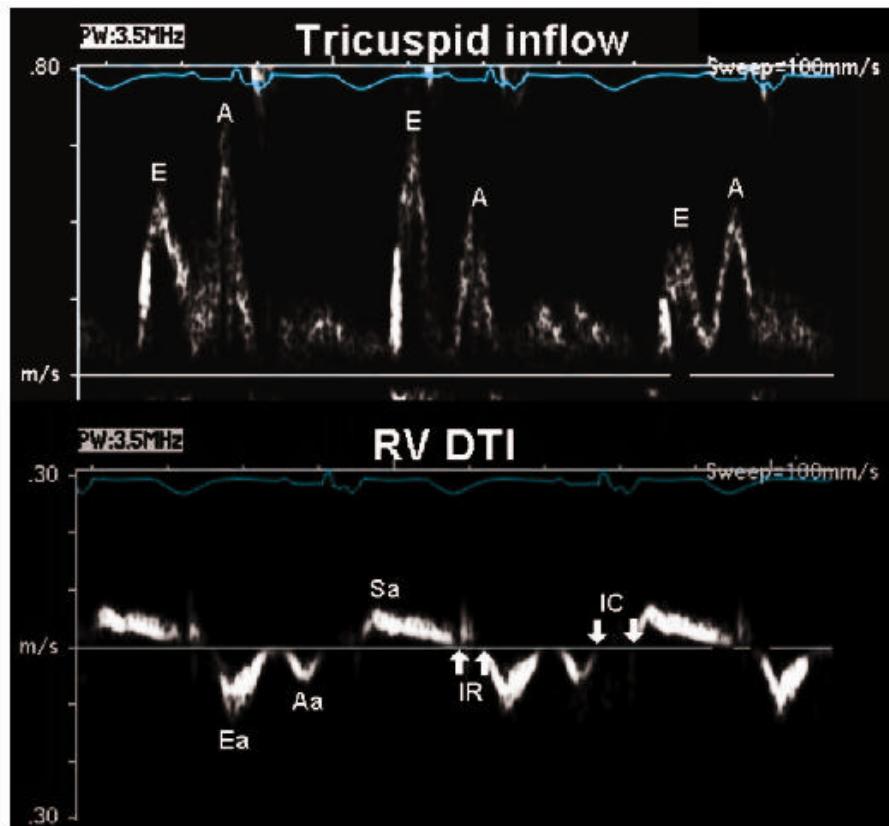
Tricuspid inflow Doppler (top panel) and tricuspid annular pulsed DTI (bottom panel) recordings from a child with tetralogy of Fallot after repair with severe pulmonary insufficiency. The tricuspid inflow Doppler pattern is difficult to interpret because of marked variations in velocities with changes in respiration. In contrast, the DTI tracing is stable throughout the respiratory cycle, reflecting the preload independence of annular motion. In addition, both systolic indexes of annular motion, such as peak systolic velocity (*Sa*) and isovolumic contraction (*IC*), and diastolic indexes of annular motion, such as early diastolic velocity (*Ea*), diastolic velocity with atrial contraction (*Aa*), and isovolumic relaxation (*IR*), are measurable from the DTI trace.
